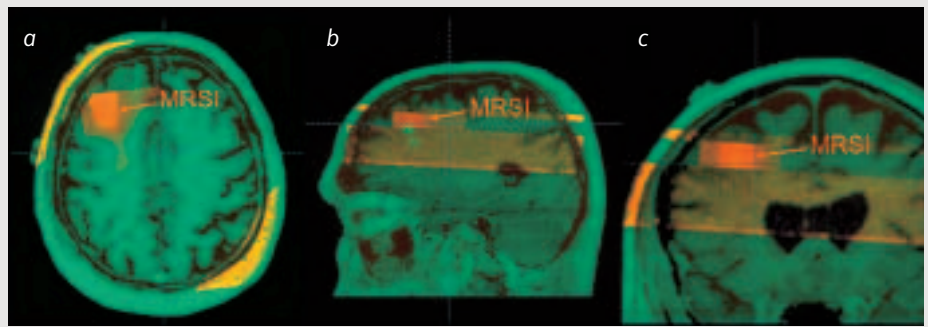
Image fusion of metabolic maps (MRI/MRSI hybrid data set, in orange) to a 3D-MRI dataset (in green) of a patient with an oligodendrogliom (WHO grade III). The result is a 3D-MRI consisting of anatomical and metabolic information for surgical planning. A: Axial, B: sagittal and C: coronal reconstruction of the 3D data set after image fusion, respectively. (Note: The small light green rectangles below the MRSI (orange) in (B): are results of a MEG examination (language stimulation).
